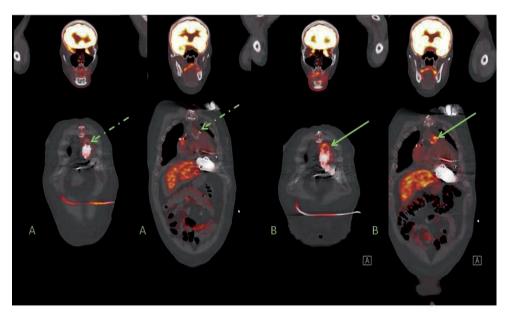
Case BIII, 61-years-old male with example of a deep driveline infection; Driveline in situ with subcutaneous fat infiltration visible around the course of the line in the abdominal wall (dotted green arrows). 3B. In case B III, the second ¹⁸F-FDG PET/CT showed 54 days later persisting and increased metabolic activity around the subcutaneous driveline in abdominal wall. Furthermore appearance of increased metabolic activity around the outflow cannula of the LVAD near to ascending aortae (green arrows).
